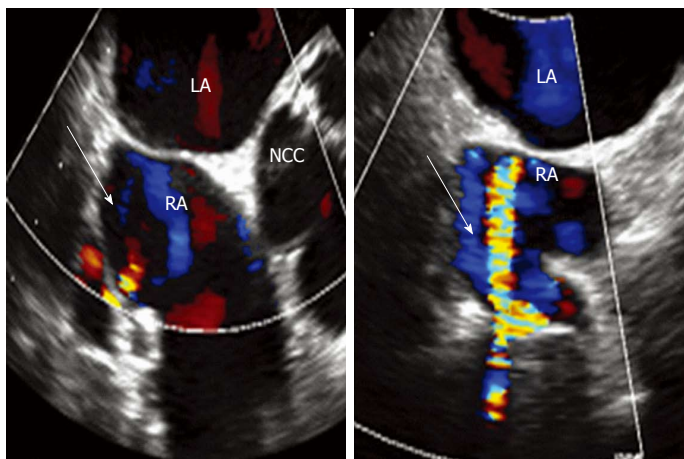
Transesophageal echocardiogram-mid esophageal view, short axis, at -30 degree view, with slight clockwise rotation. White arrow points to the abnormal vascular communication noted to the right atrium on transesophageal echocardiogram. LA: Left atrium; RA: Right atrium; NCC: Noncoronary cusp.
